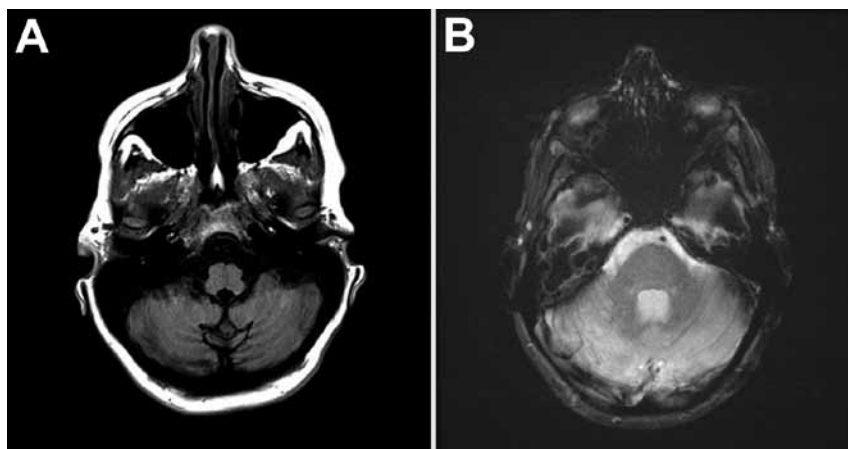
A) Magnetic resonance images of the brain of a woman with cerebellitis associated with influenza A(H1N1)pdm09, United States, 2013. T1-weighted axial MRI brain sequence showing hypo-intensity of bilateral cerebellar hemispheres. B) T2-weighted axial MRI brain sequence showing hyperintensity of bilateral cerebellar hemispheres.
